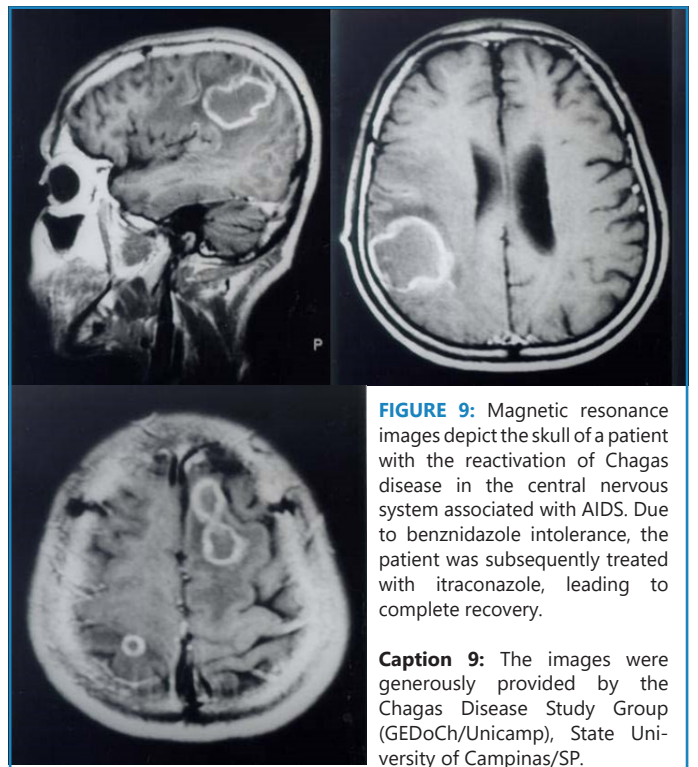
Magnetic resonance images depict the skull of a patient with the reactivation of Chagas disease in the central nervous system associated with AIDS. Due to benznidazole intolerance, the patient was subsequently treated with itraconazole, leading to complete recovery.
